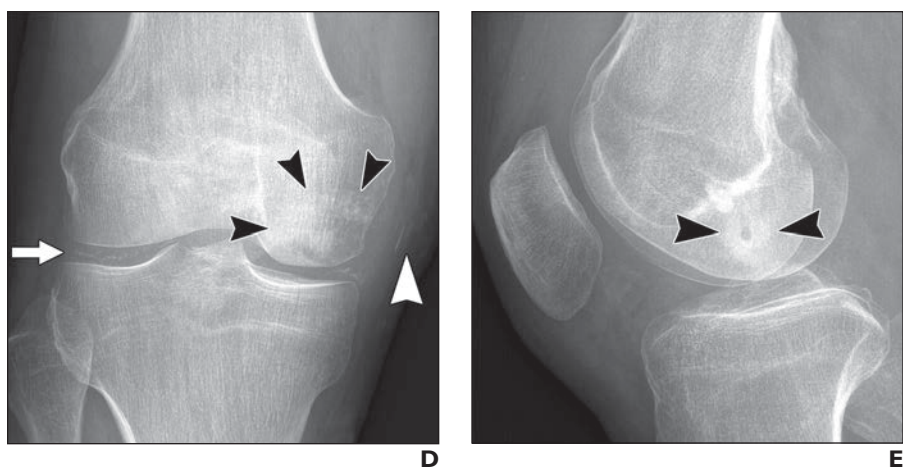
53-year-old male runner with persistent pain and weakness in right knee after medial meniscectomy 4 months earlier. A, Preoperative coronal intermediate-weighted fat-saturated MR image (TR/TE, 3000/33) shows large area of bone marrow edema in medial femoral condyle (arrow) and small subchondral hypointense line parallel to cortex (arrowhead), which are consistent with insufficiency fracture. B, Intraoperative fluoroscopic image shows lateral approach and needle placement (arrow) during subchondroplasty. C, Postoperative radiograph shows focal region of opacification in medial femoral condyle (arrowhead) and prominent soft-tissue contamination (arrow) along lateral approach.
